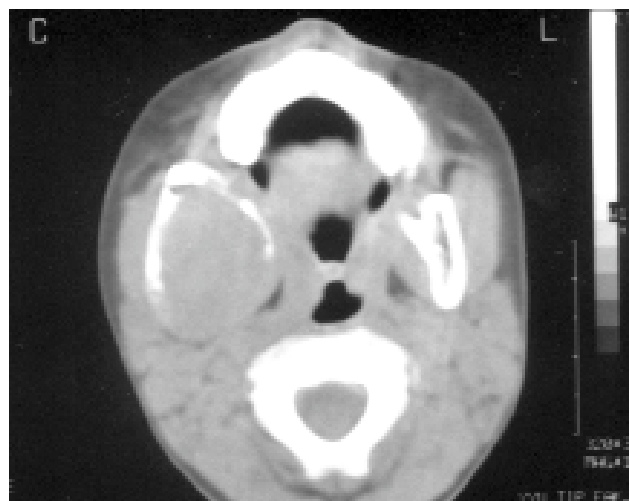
Computed tomography view of the mandible showing an expansive radiolucent lesion with a lytic process.
